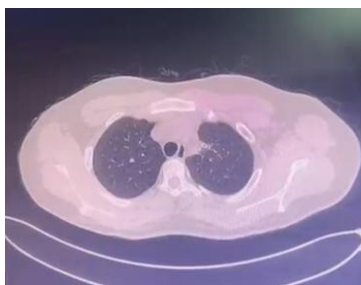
follow up CT scan of patient after anti tubercular therapy.
